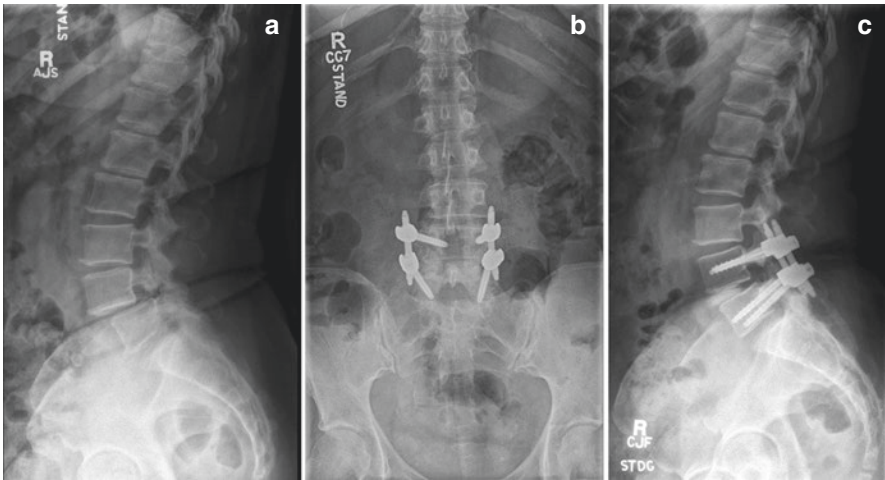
A 71-year-old female patient presenting with pseudoclaudication and left leg pain. Preoperative X-ray (a) showed spondylolysis at L4 with grade II spondylolisthesis L4 on L5. Following MI-TLIF, postoperative X-rays (AP (b) and lateral (c)) showing L4-L5 fusion with posterior instrumentation and reduction of the slippage
